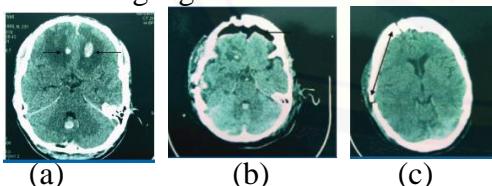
(a) Axial CT scan of the head using a slice thickness of 1.2 mm in TBI patients (black arrows indicate hemorrhagic contusions in bilateral
